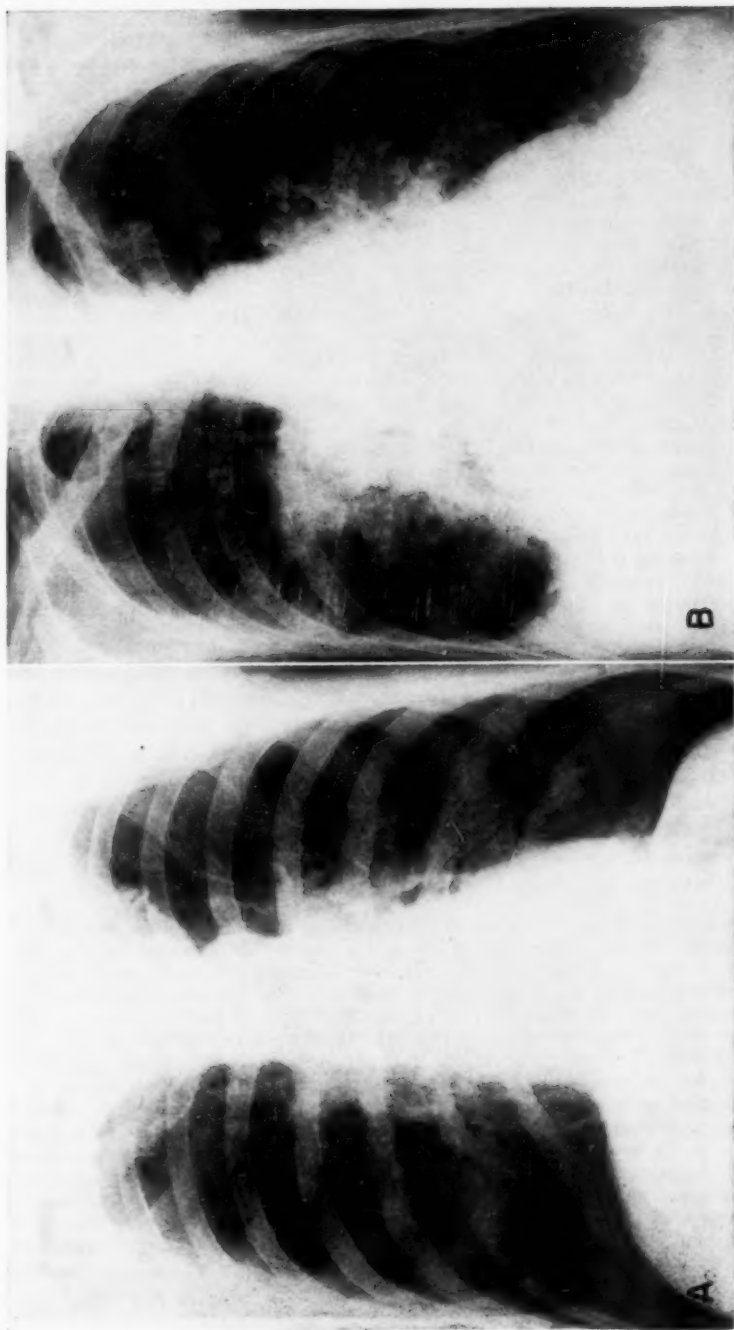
Case 2. Roentgenograms of the chest. A. Early in the illness. B. Late in the course of the disease showing striking perihilar changes, cardiac enlargement and fluid at both bases.
